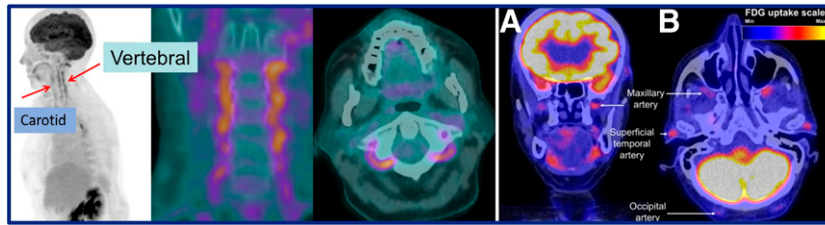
^{18}F -FDG PET findings in craniofacial giant-cell arteritis (GCA). Uptake was seen around the posterior elements of C1 and C2 within the transverse foramina of the cervical spine in the vertebral arteries and in smaller vessels, including the maxillary, superficial temporal, and occipital arteries. ^{18}F -FDG PET/CT showed high accuracy in craniofacial GCA diagnosis, with the potential to guide clinicians in early treatment decisions.
